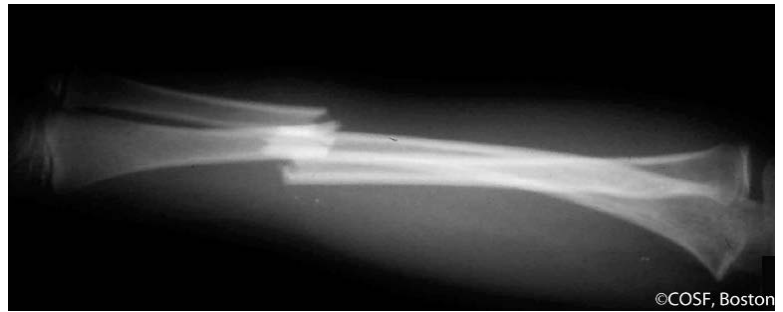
Representative radiographs of the initial both bone forearm fracture of Case #1. (Figures courtesy of Children's Orthopaedic Surgery Foundation)
